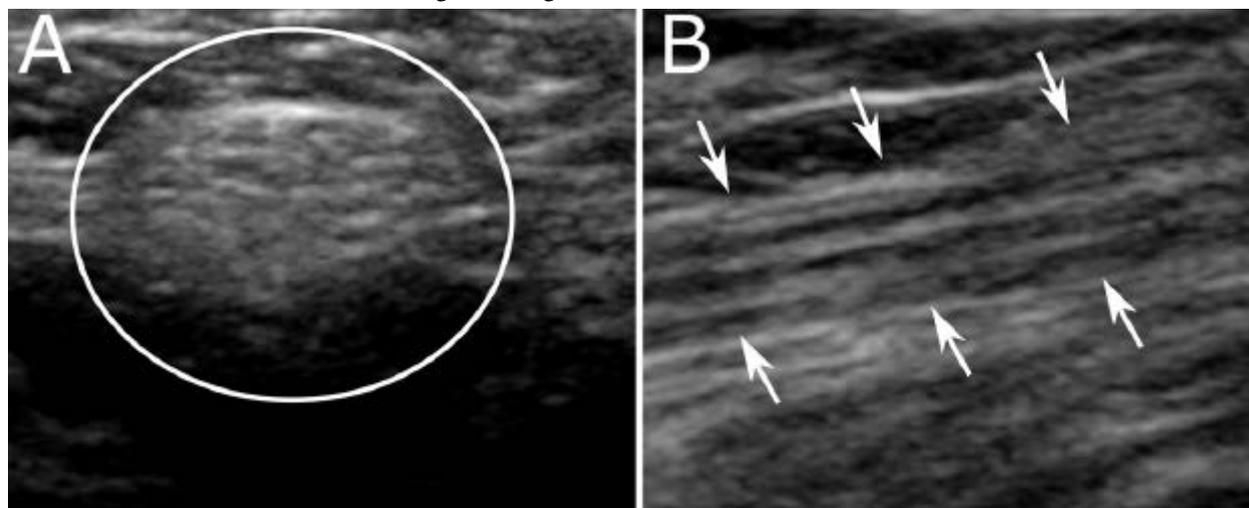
Normal ultrasound appearance of the sciatic nerve. Transverse image (A) demonstrates small rounded hypoechoic fascicles surrounded by hyperechoic perineural fat. Longitudinal image (B) demonstrates a "tram-track" appearance of the nerve, with alternating hypoechoic fascicles and hyperechoic perineural fat.
